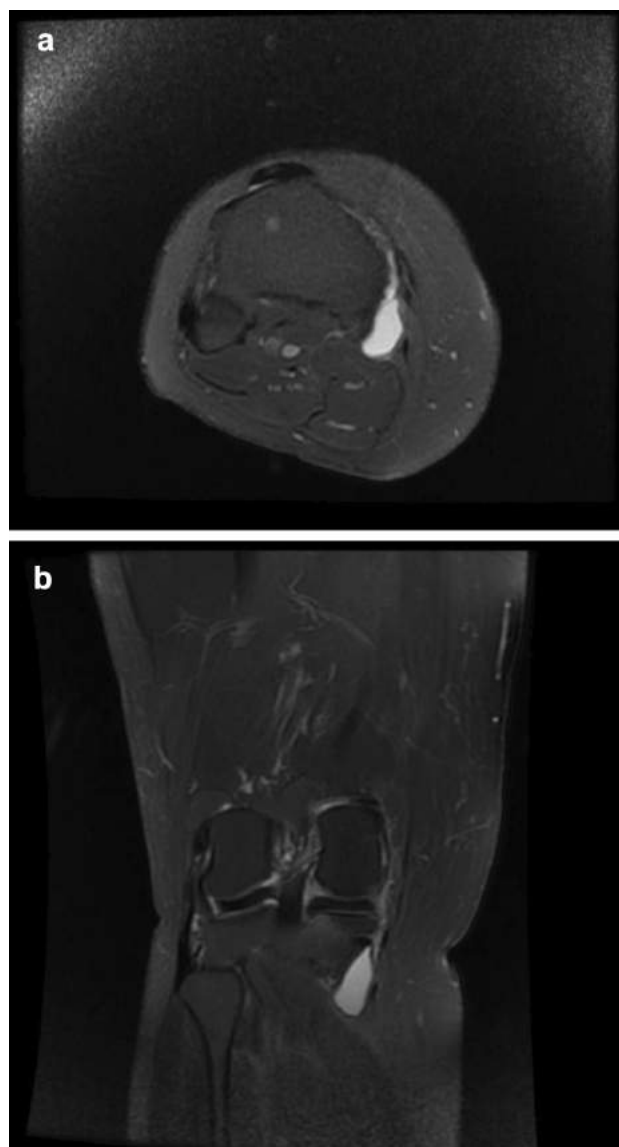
Axial (a) and coronal (b) FS PD-weighted MR images of the knee in a 67-year-old male patient showed thickened pes anserine tendons which have with increased intrasubstance signals and edema with minimal effusion adjacent to the tendon
